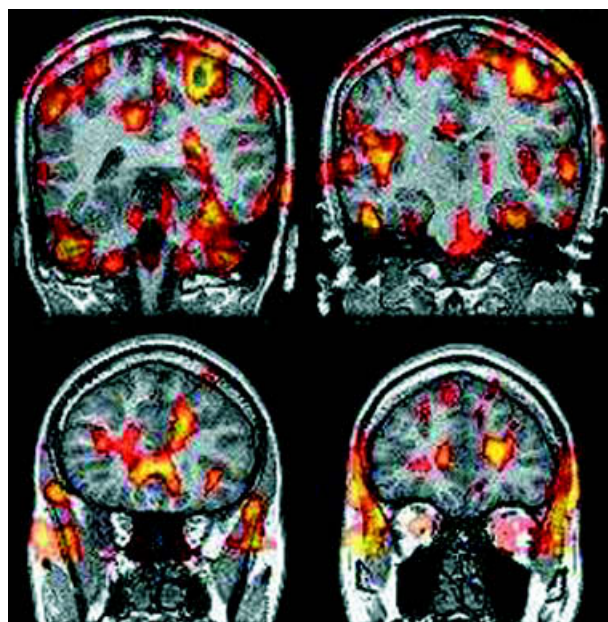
Ictal single-photon emission computed tomography subtraction image, obtained by subtraction, normalization, and coregistration, shows multiple areas of perfusion increase in parietal and frontal lobes in a patient with epilepsy in the superior parietal/medial frontal network.
